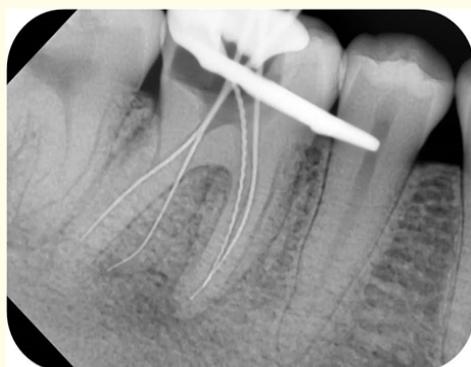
Working length IOPA radiograph of tooth #46 straight on angulation.
